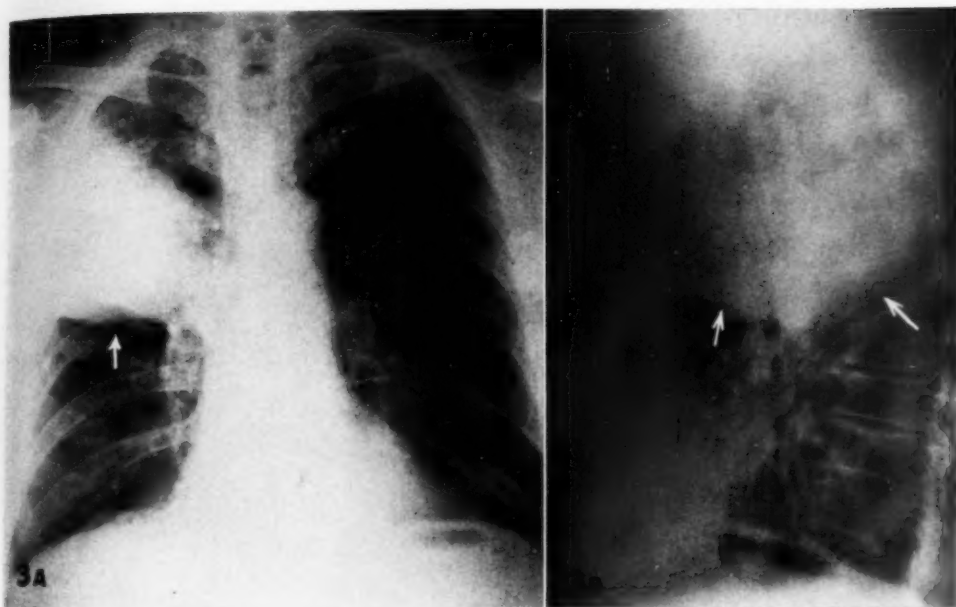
(W. K.). Right upper lobe Friedländer's pneumonia forty-eight hours after onset. The correct diagnosis was suggested from the roentgen findings. A. Postero-anterior view showing downward bulge of minor fissure (arrow). B. Right lateral view, showing bulging of both major and minor fissures (arrows).
